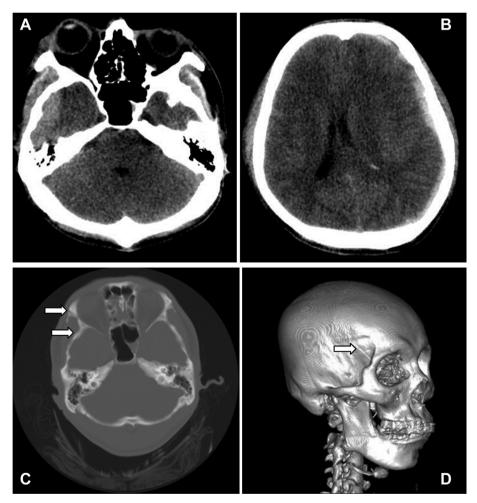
Initial computed tomography showing (A) a small right temporal epidural hematoma (thickness: <1 cm), (B) left temporal subdural hematoma with a midline shift, (C) and (D) a right temporal bone fracture (arrows).
